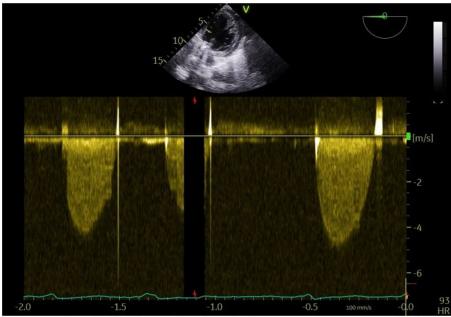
Spectral Doppler of the left ventricular outflow in the deep transgastric long axis view immediately post cardiopulmonary bypass after initial mechanical aortic valve implantation.
